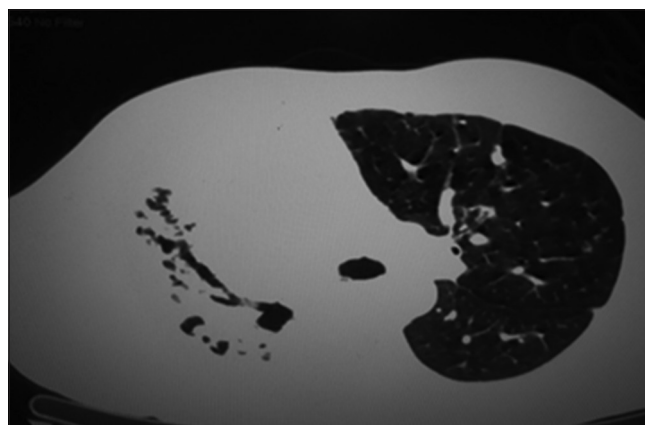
Computed tomography thorax lung window image showing parenchymal scarring with traction bronchiectasis in right lung
